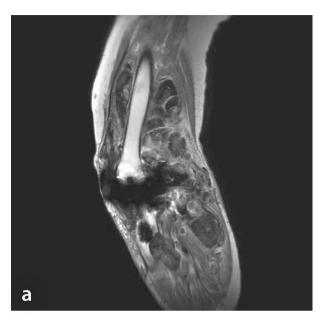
Sagittal T1-weighted MR image, turbo spin echo, after intravenous contrast injection in a 69 year old female patient with recurrent, end stage TGCT on the right side. Extensive tumour growth around her total knee replacement (TKR), involving the entire kneejoint: anterior and posterior, ranging from high up supra-patellar pouch to below tibia-fibular joint, including bone-involvement.
